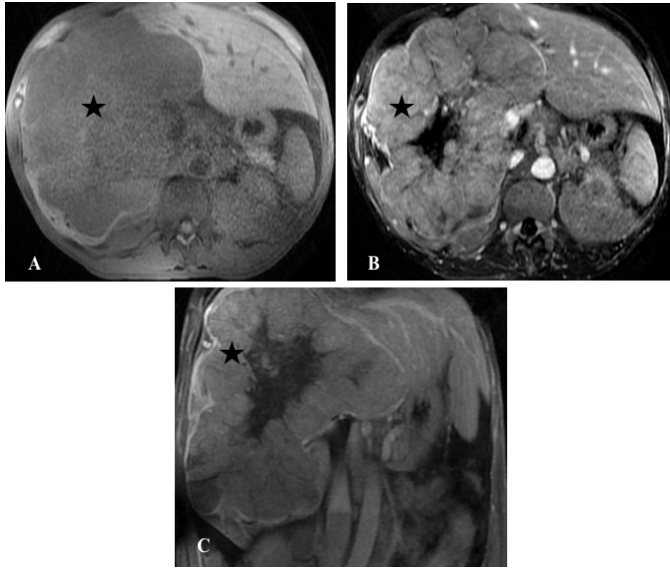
MRI images at initial diagnosis: A) fat-suppressed pre-contrast T1-weighted series, transverse plane; B) fat-suppressed T1-weighted series, arterial phase, transverse plane; C) fat-suppressed T1-weighted series, parenchymal phase, coronal plane.
